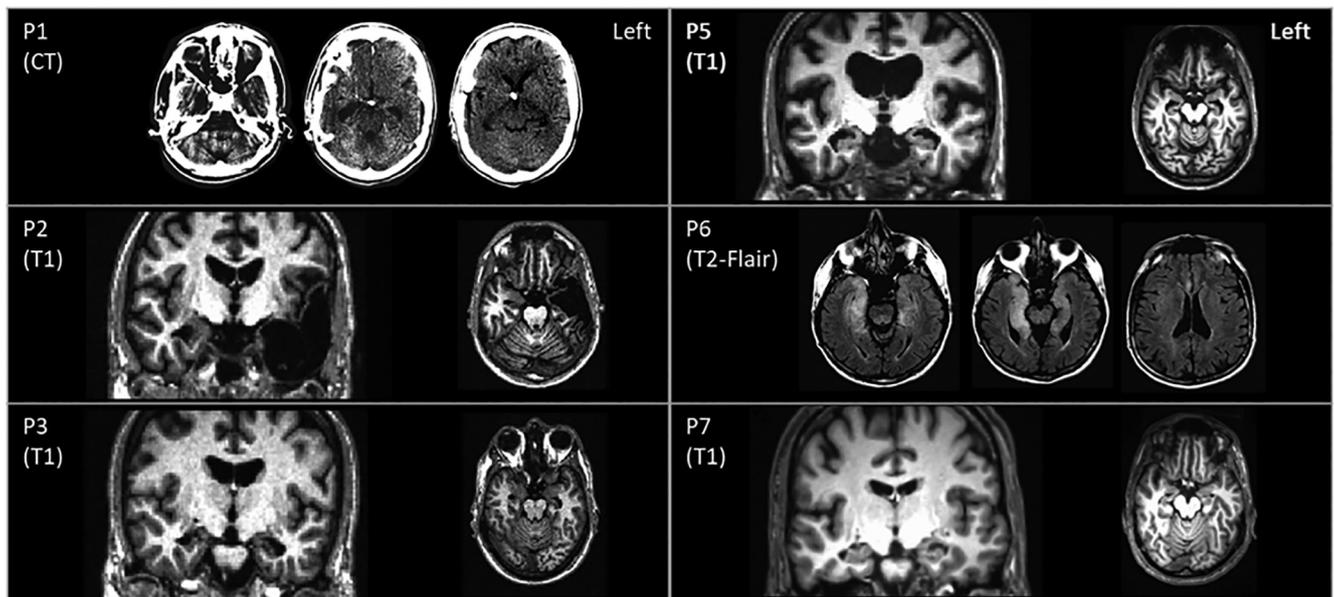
Brain imaging of the medial temporal lobe (MTL) lesions of the patients with amnesic syndrome included in the present study. Imaging modality varied depending on availability. Available images include CT slices in the axial plane (P1), T1-weighted MRI images in the coronal and axial plane (P2, P3, P5, and P7), and T2-Flair MRI images in the axial plane (P6). Imaging could not be collected for P4 because of medical contraindication.
